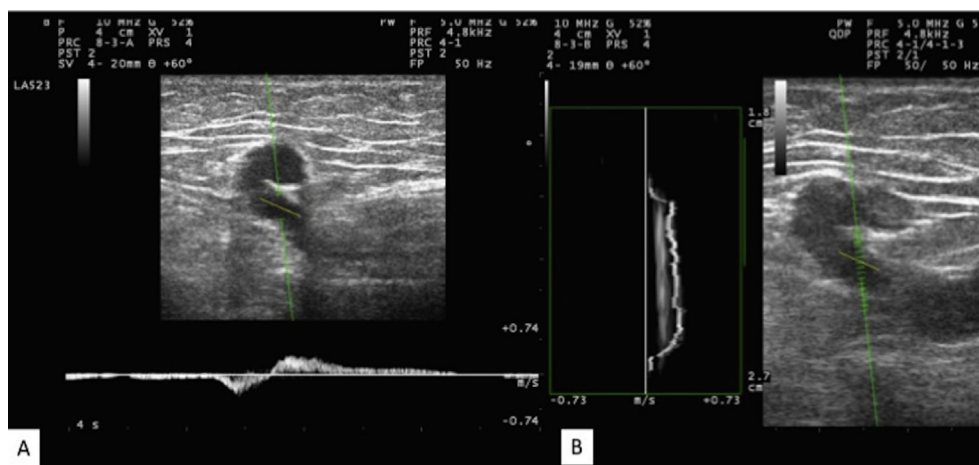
Comparison between pulsed wave (PW) (A) and quality Doppler profile (QDP) (B) analysis in a tortuous perforating vein. The single gated analysis with the PW produces a bidirectional spectrum (A) that is translated by QDP multigate analysis into a monodirectional curve reporting the net inward/outward direction. While in the PW (A) analysis the direction of the vessel and the consequent steering influence the assessment outcome, in a QDP analysis the flow detection is independent of the vessel tortuosity because the Doppler signals of multiple sample volumes are analysed simultaneously.
